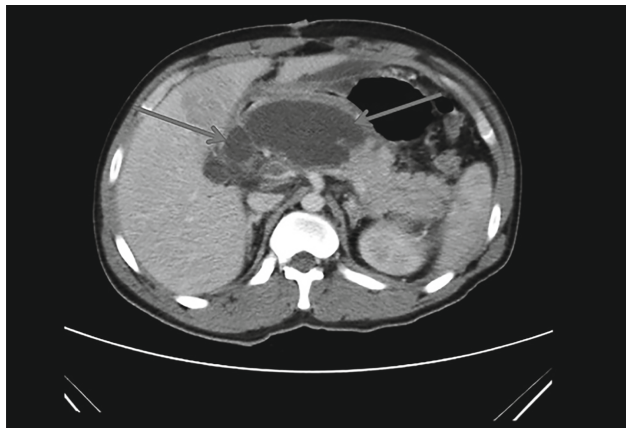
CT image showing large lobulated pancreatic pseudocyst
